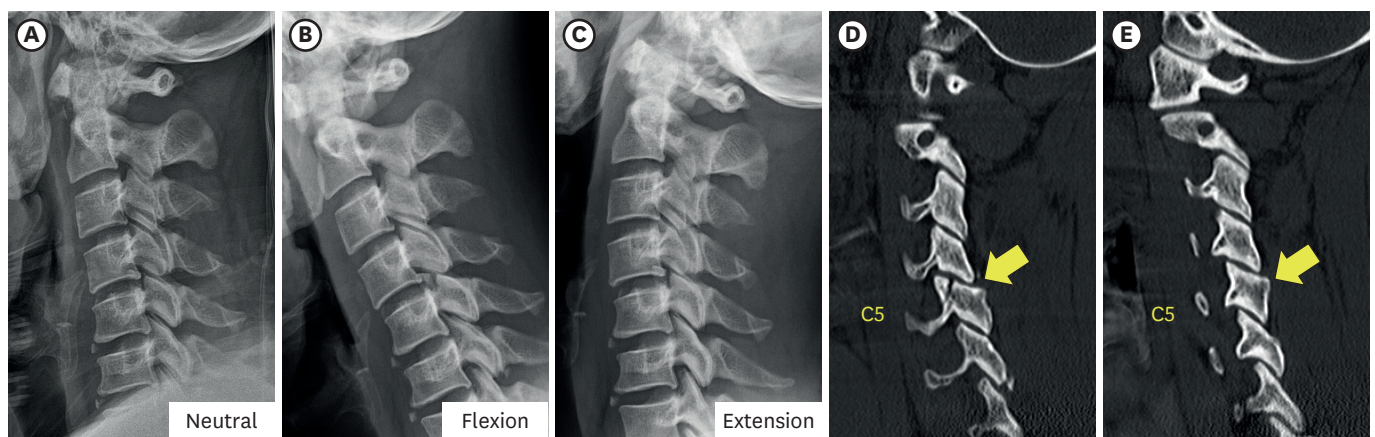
Initial presentation of the patient. Initial C-spine lateral X-ray (A), flexion (B), extension (C). Sagittal image of C-spine CT on injury day showed right C5 superior articular process fracture without displacement and dislocation (D). Contralateral, left facets were all intact (E). Yellow arrow: C5 vertebra.
